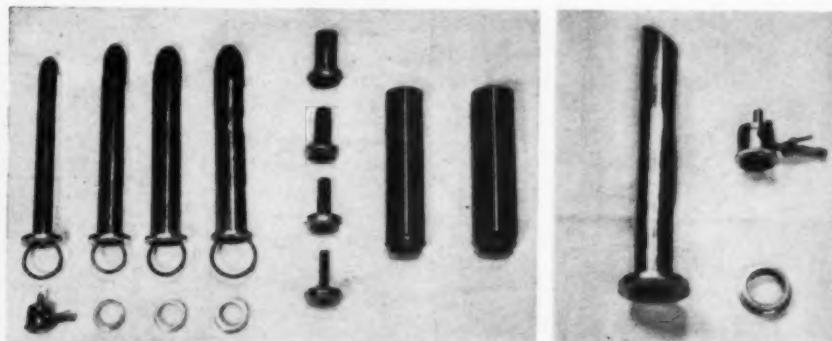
Assortment of cylinders, obturators, adaptors, and the eye piece used in intra-ovarian roentgen irradiation.
